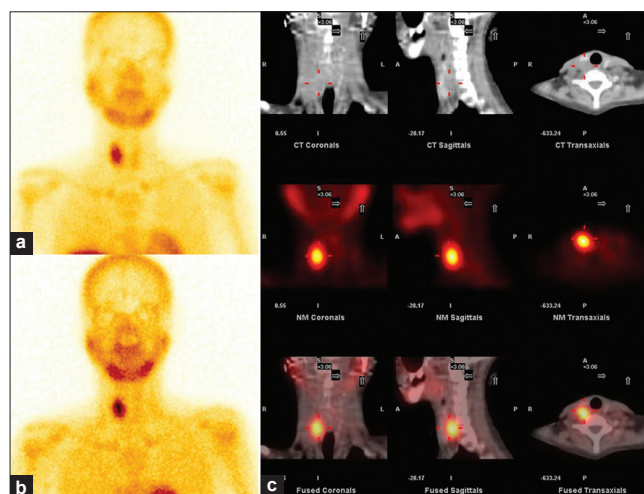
A 37-year-old female presented with elevated calcium and decreased phosphorus and increased parathyroid hormone (PTH). USG neck showed right superior parathyroid adenoma. Tc99m sestamibi scan (a) early images show increased tracer uptake in the area corresponding to the right lobe of the thyroid and faint tracer uptake in the left lobe of the thyroid gland; (b) delayed images show retention of tracer in the right side. Wash out of tracer is noted from the left lobe of thyroid. (c) SPECT/CT images localize increased tracer uptake to the posterior aspect of right lobe of the thyroid and CT shows the adenoma
